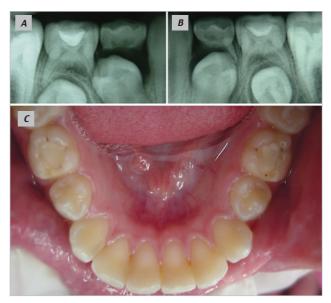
(A and B) Radiographic views of the primary first molars at 12 months. (C) Clinical view of the premolars after 16 months.
